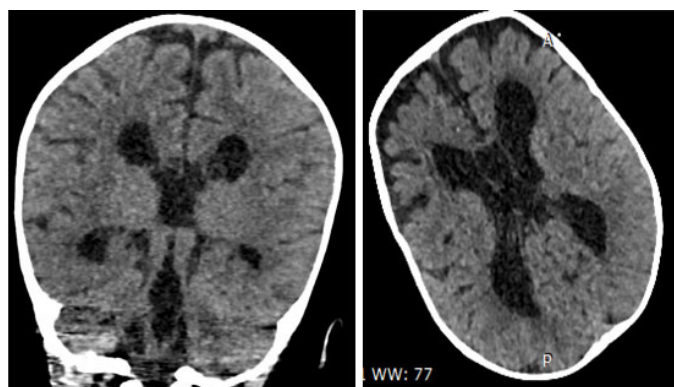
Axial view non-enhanced brain CT: Complete agenesis of corpus callosum, cavum septum pellucidum, triventricular hydrocephalus.
